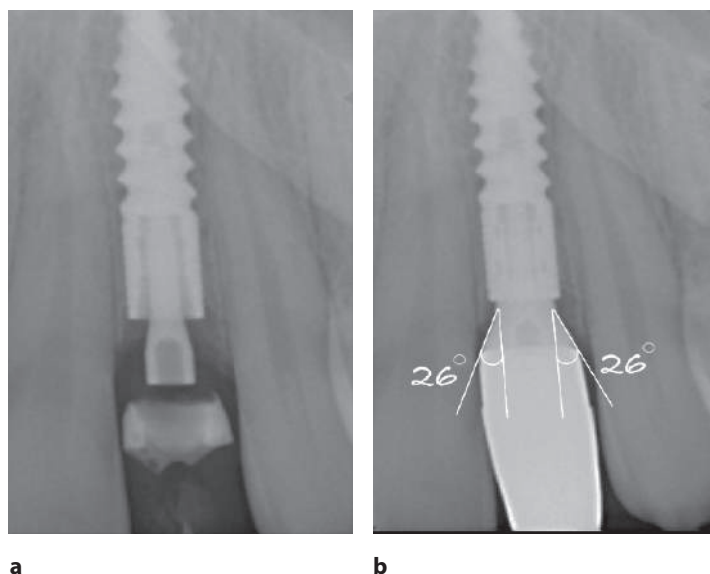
X-ray image: a) 16 weeks after surgery with temporary plastic abutment; b) after 5 years of functionality. The emergence angles of permanent abutment are 24 degree
